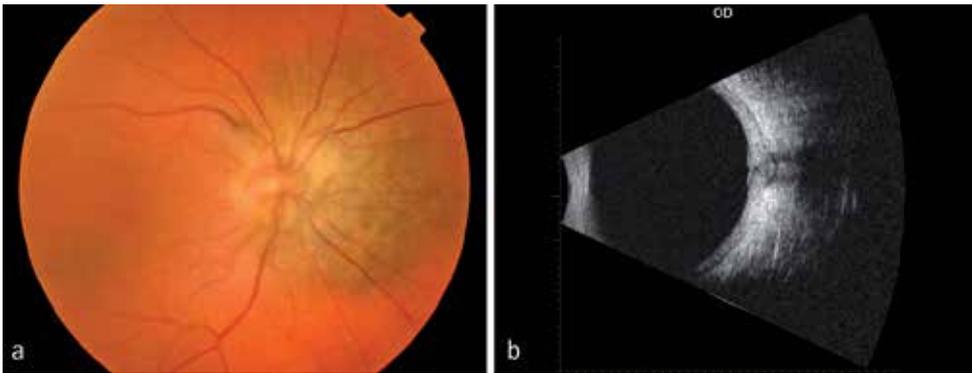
a: Peripapillary nevus, barely elevated, with margin located < 3 mm to the optic disc in the right eye of a 72 year-old man; 4b: High reflectivity on B-scan ultrasonography.
